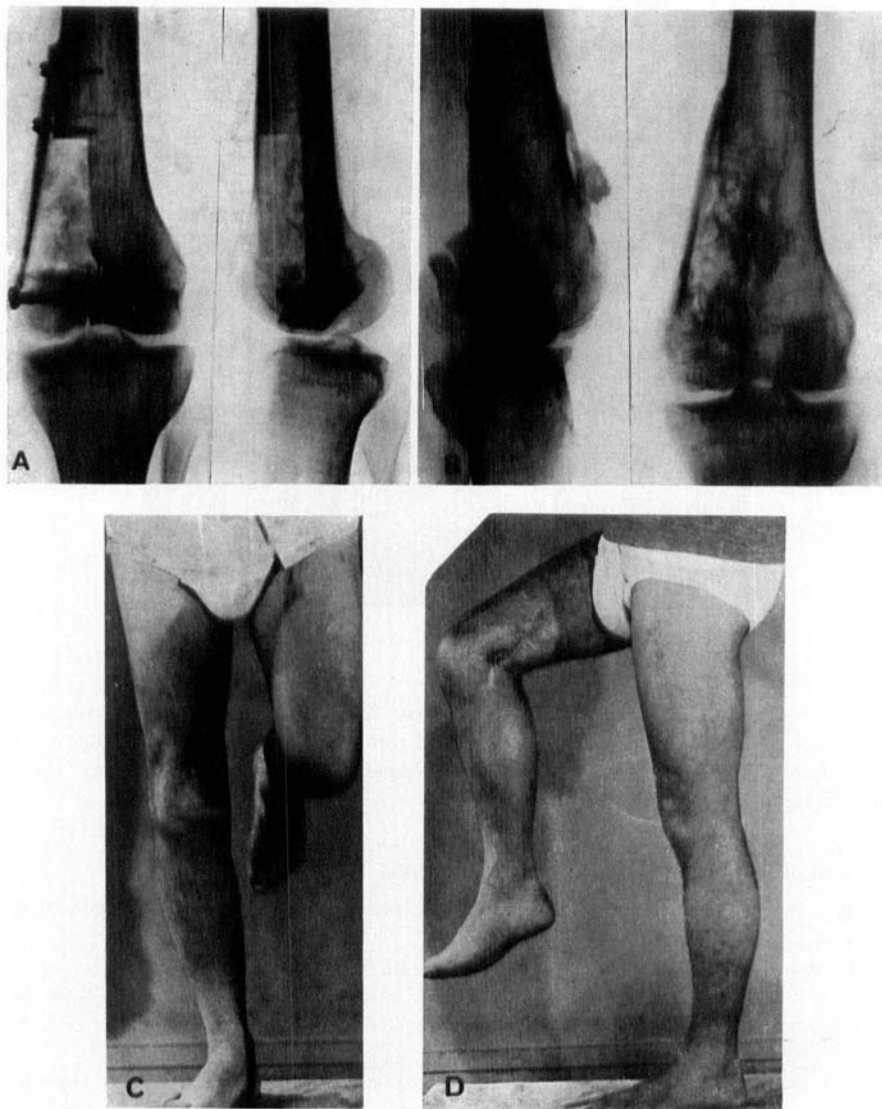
Case 3. Male 31 years. Giant cell tumour of medial femoral condyle. A: X-ray after reconstruction by pedicled patella, tibial graft and cancellous grafts. B: X-ray 7 years post-op. C-D: Mobile and stable right knee.
